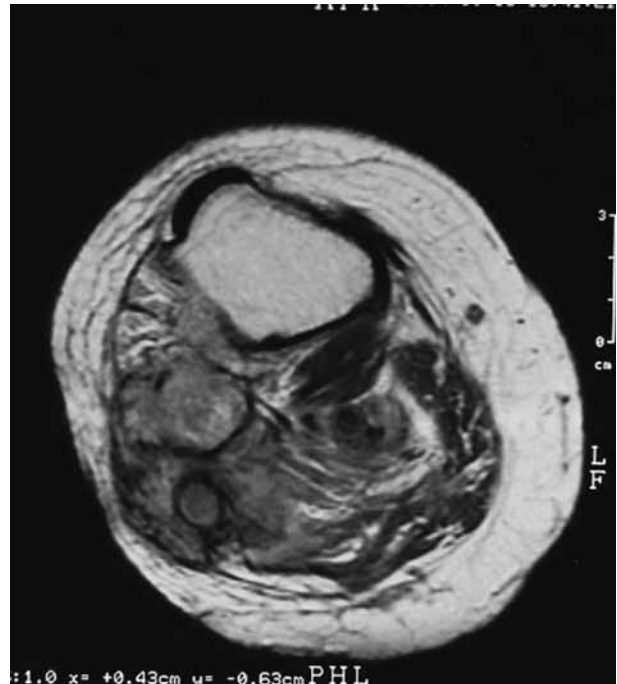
This post-contrast axial T1-weighted magnetic resonance image reveals invasion of anterior, lateral and deep posterior compartments and involvement of the local neurovascular structures. Contrast enhancement of the tumour is also apparent.
